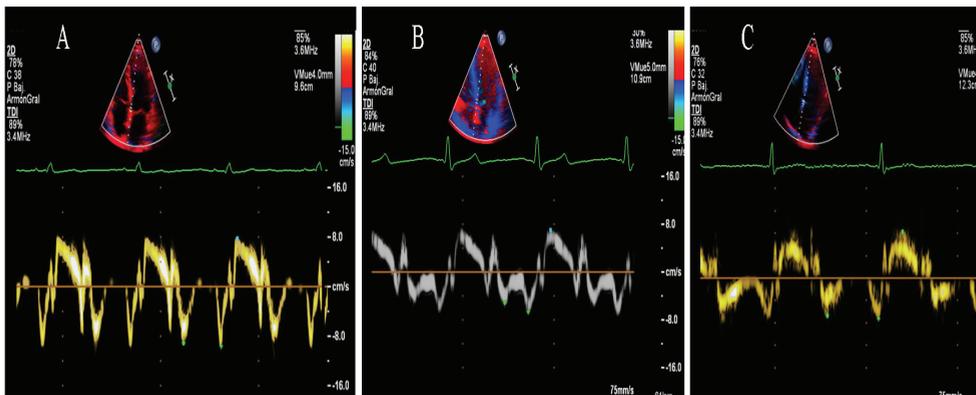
Doppler tissue imaging of mitral annular motion: A) Impaired relaxation pattern, B) Pseudonormal pattern C) Restrictive pattern
